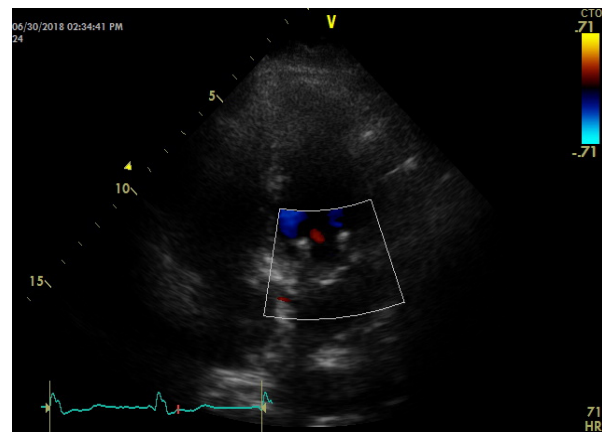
Parasternal short axis (PSAX) view (a) note the posterior P2 segment is prolapsed at the onset of systolic phase (b) color flow demonstrate regurgitation at the start of the systolic phase
